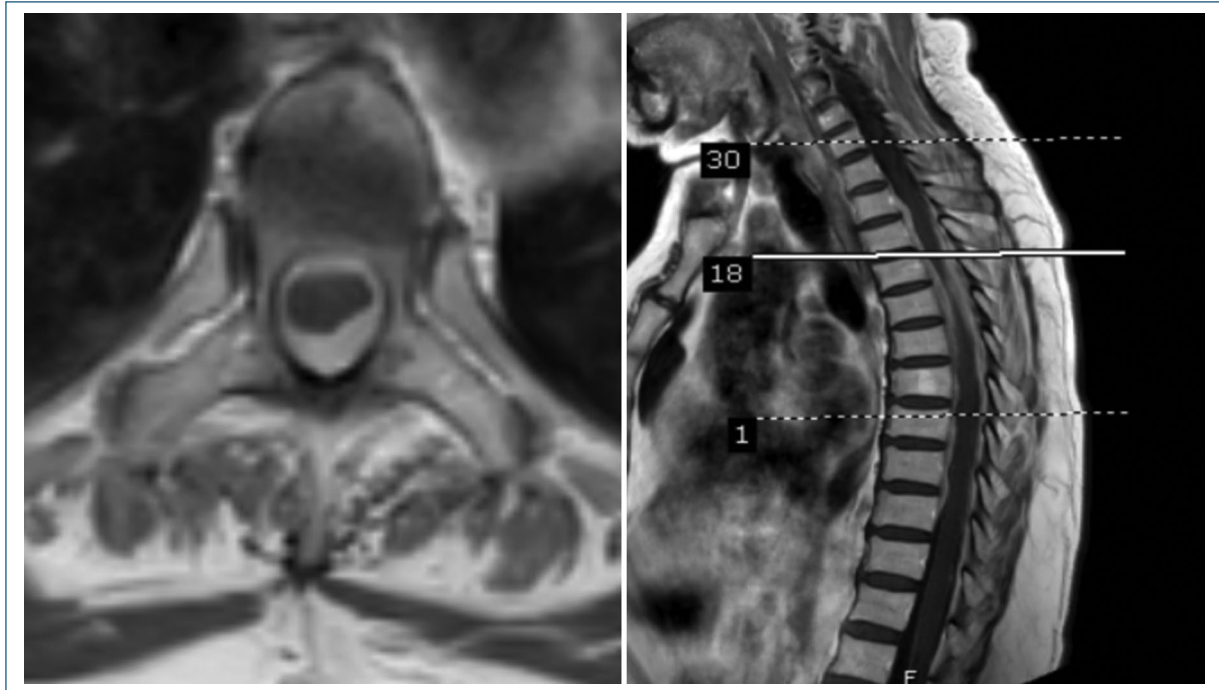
Axial T1-weighted MRI at T5-T6 showing an intradural extramedullary lesion causing spinal cord compression (left) and sagittal view (right) showing increased volume and contrast enhancement from T2 to T10 in the anterior and posterior spinal regions.
